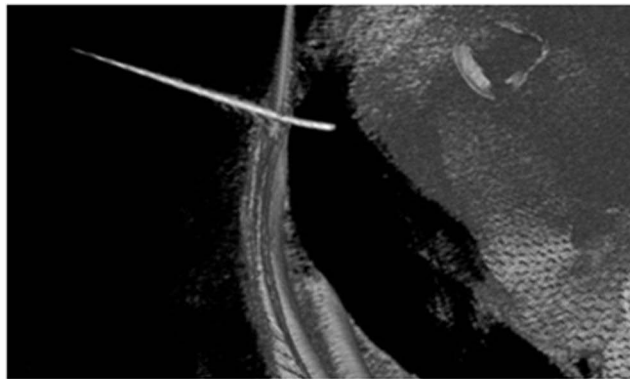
3D CT of the cannula position.
